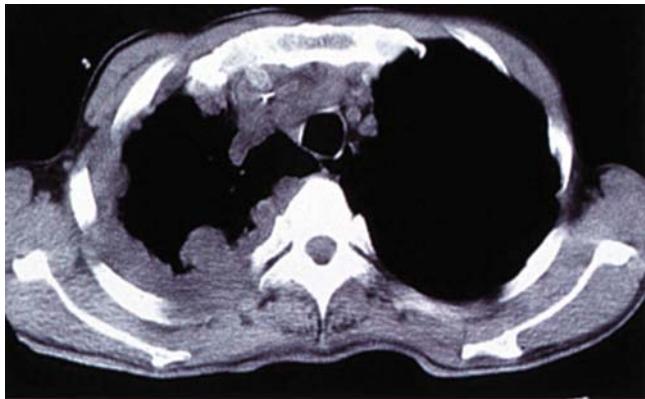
CT of chest showing irregularly shaped pleural-based tumor mass following the contour of the chest wall. Reproduced with permission from *Acta Medica Okayama*, see chapter references for complete citation.
